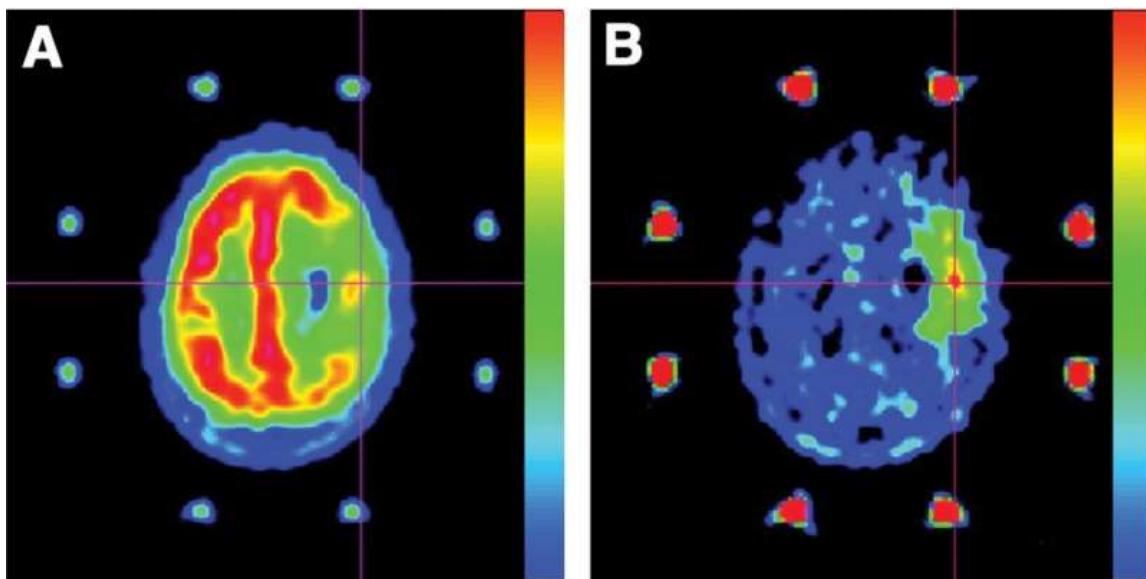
PET scan of a patient's brain with tumour by using ^{18}FDG (left) and ^{11}C -MET (right)
